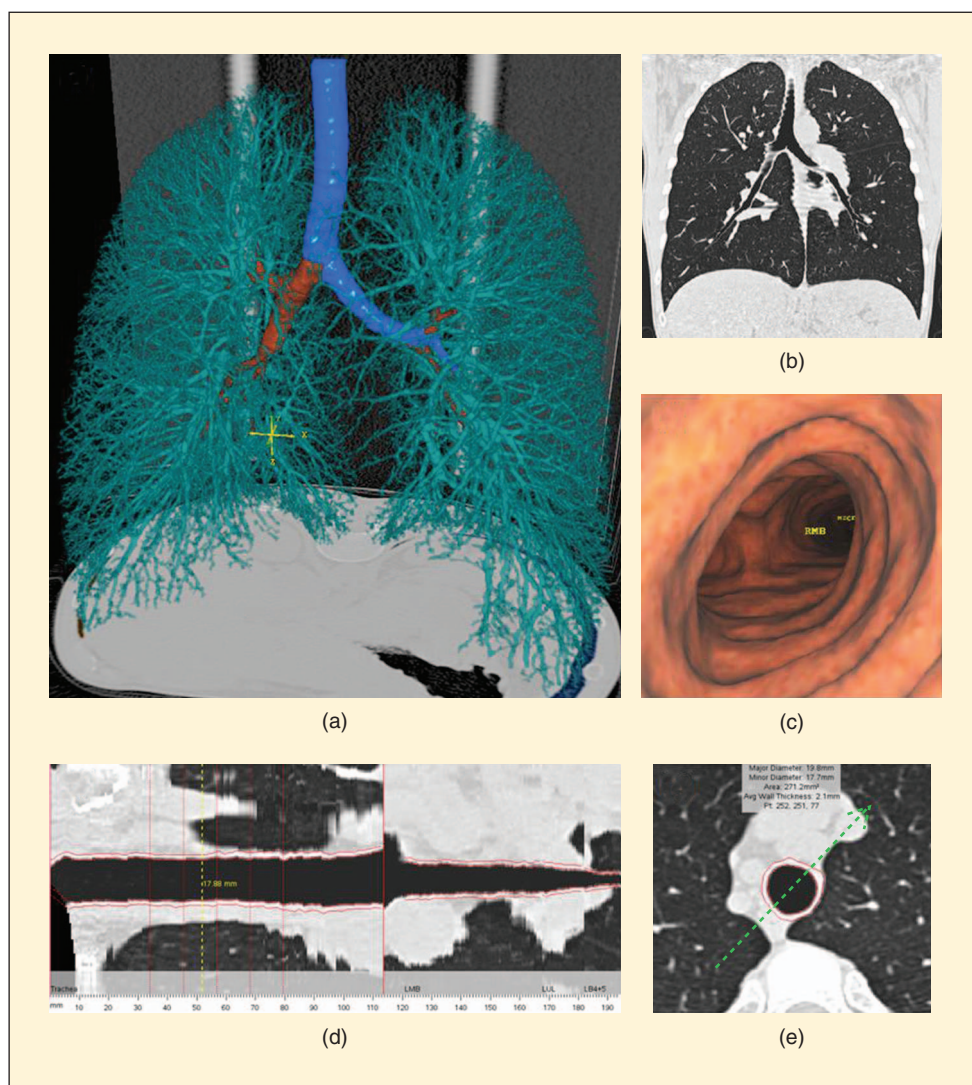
(a) 3-D surface rendering of airway (blue and brown) and vessel (cyan) trees of a human subject, (b) coronal view of CT data, showing the trachea, the main-stem bronchi, and the lung tissue, (c) virtual flythrough of the trachea facing the first bifurcation (right main-stem bronchus (RMB)), (d) axial cross-sectional view along the blue color-coded airways in (a), which is chosen arbitrarily, and (e) perpendicular view of the airway along the yellow dashed line in (d).
